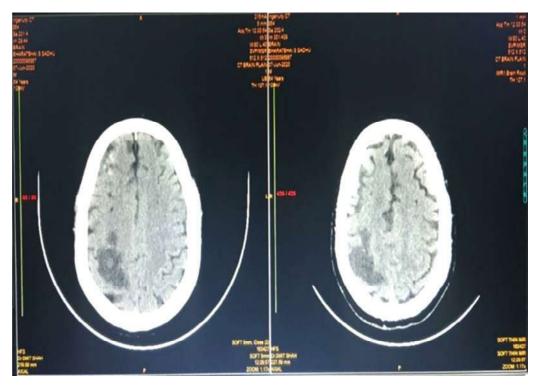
CT brain (Axial cut) showing hypodensity in right parietal region.
